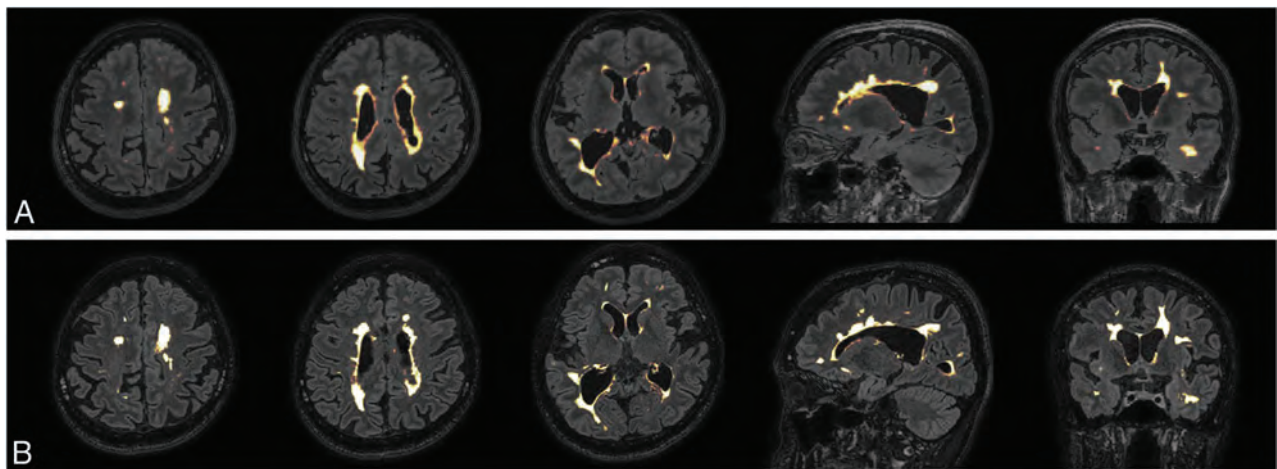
Representative examples of lesion segmentation in a 35-year-old woman with MS. Lesions were automatically segmented on synthetic and conventional FLAIR images. The segmented lesions are overlaid on the images used for segmentation. *A*, Lesions overlaid on 3D synthetic FLAIR images. *B*, Lesions overlaid on conventional 3D FLAIR images. Minimal differences are observed between segmented lesions of 3D synthetic and conventional FLAIR images.
